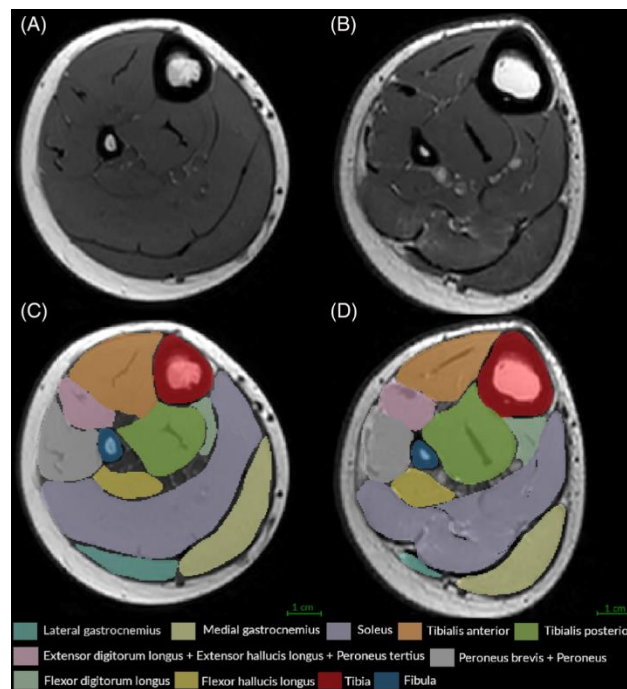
MRI scans of normal child (A) and a child with CP(B), and their corresponding manual segmentation labels (C and D, respectively). The MRI scan of normal child differs from that of a child with CP in the shapes, positions, and sizes/volumes of muscles.
